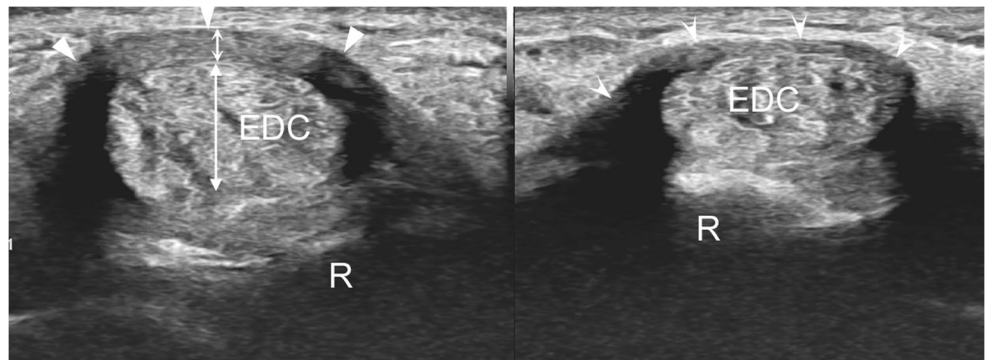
Ultrasound appearance of EDCST in the same patient as Fig. 1: Left (right wrist): transverse image showing a hypoechoic thickening (small double curved arrow) of the ER (arrowheads) and thickening and round shape of EDC (double arrow). Right: image obtained at the same level for the contralateral normal wrist. (R, radius)
